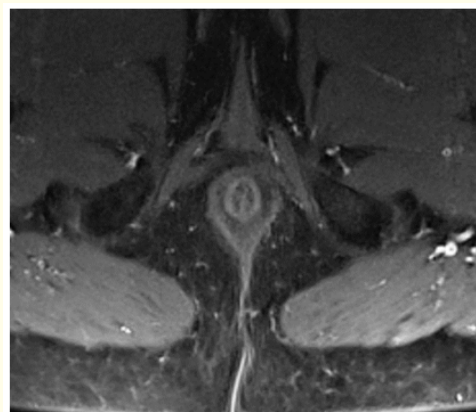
MRI 03/07/2020. Follow up after third surgery without imaging of remaining disease.
